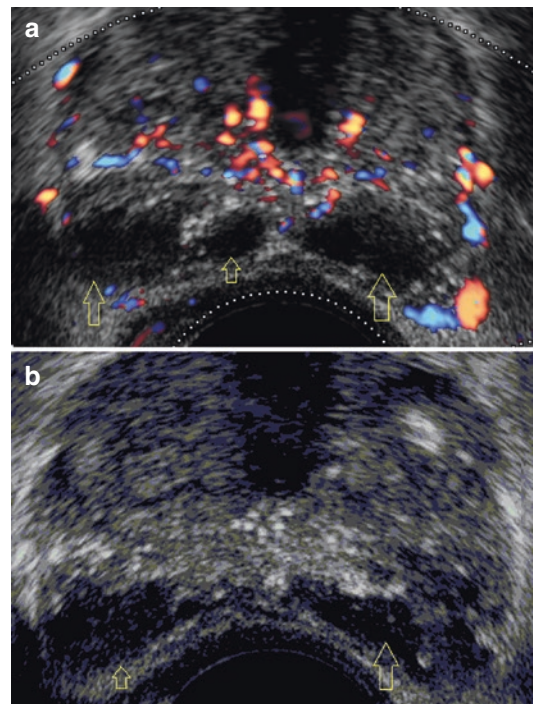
(b) Granulomatous nodules in the peripheral zone (arrows), power Doppler (a) shows perilesional vascularity
